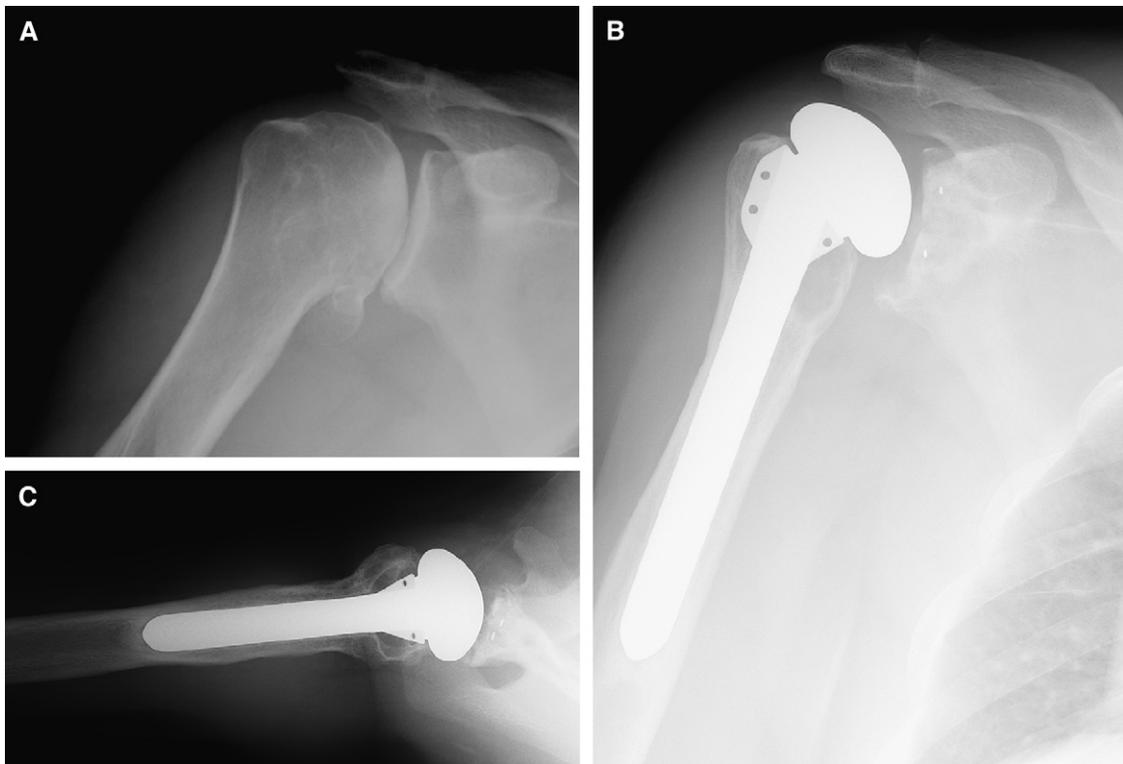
(A), Preoperative radiograph of a 48-year-old man before total shoulder arthroplasty. He had severe pain, active elevation to 70° , and passive external rotation of 0° . (B) and (C), Radiographs taken 7.8 years after surgery. The patient reported pain only after unusual activity and showed 140° of active elevation and 45° of external rotation. The glenoid component remained well fixed. However, proximal humeral osteolysis was present, which is concerning for a young patient.
